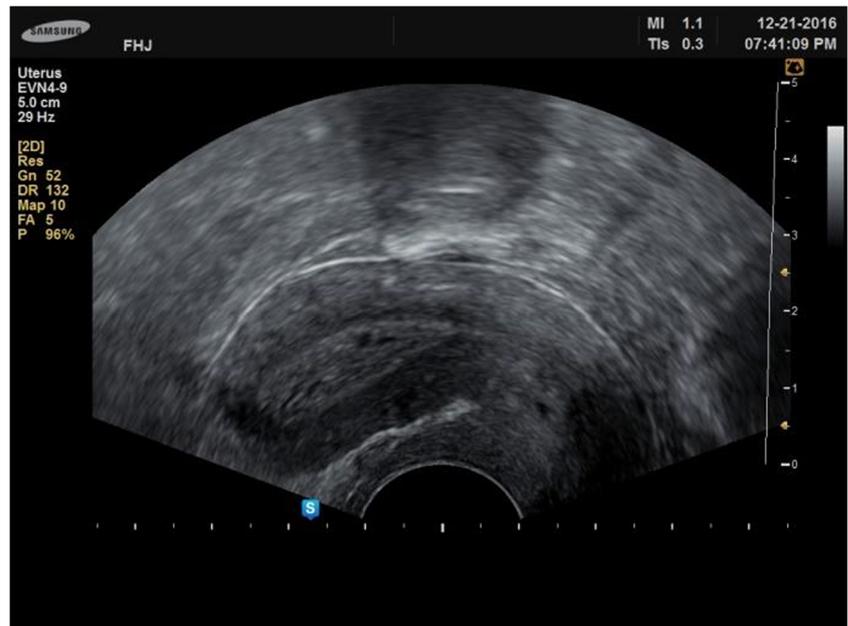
Ultrasound with turbid intrauterine fluid collection
